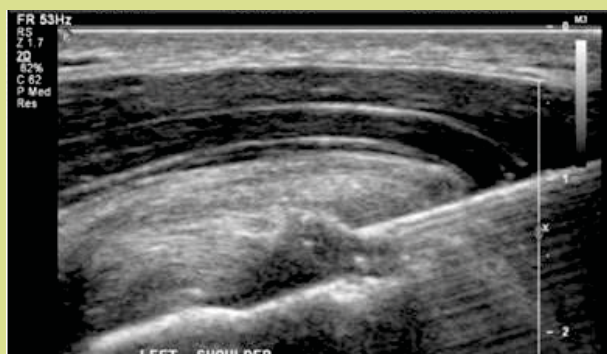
Ultrasound guided Ortho-ATI™ injection
